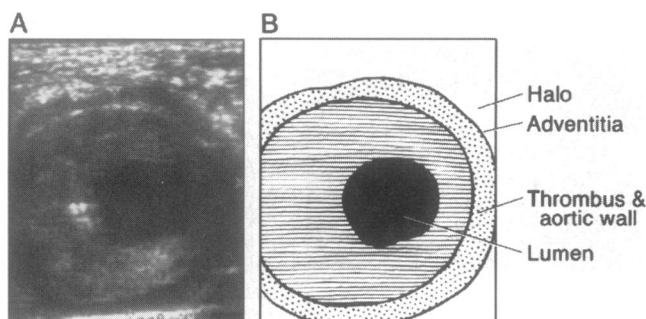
(A) Abdominal ultrasound of an inflammatory abdominal aortic aneurysm. (B) Note the "inflammatory halo" surrounding the aneurysm and its thickened wall.
